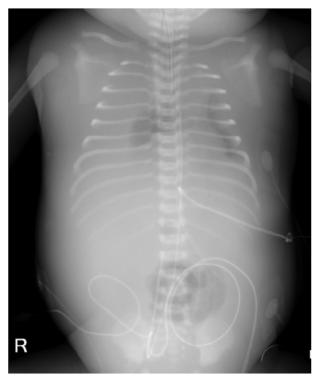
Chest and abdominal radiograph demonstrating subcutaneous edema, bilateral effusions and centralized bowel loops suggestive of ascites.
